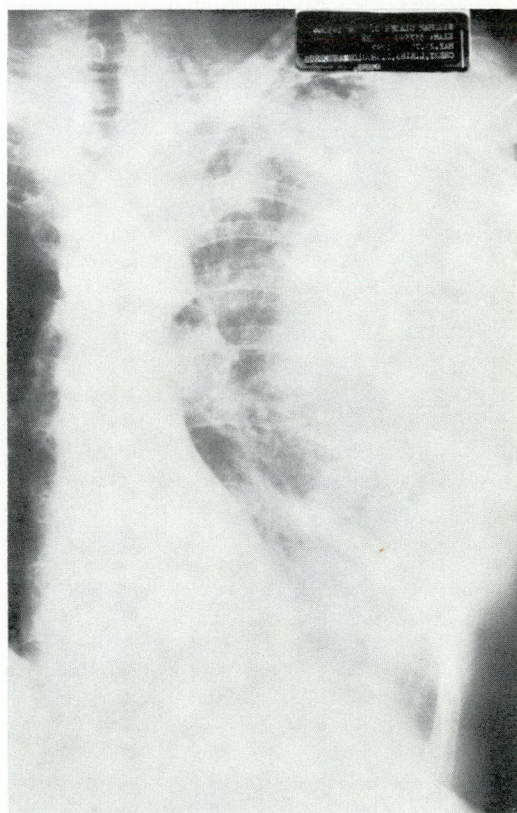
Posteroanterior radiograph demonstrating pleural effusion, fracture of the neck of the humerus with the head apparently in the thoracic cavity, fractures of the second, third and fourth ribs, and a fracture of the glenoid (note that the chest tube has become displaced).
